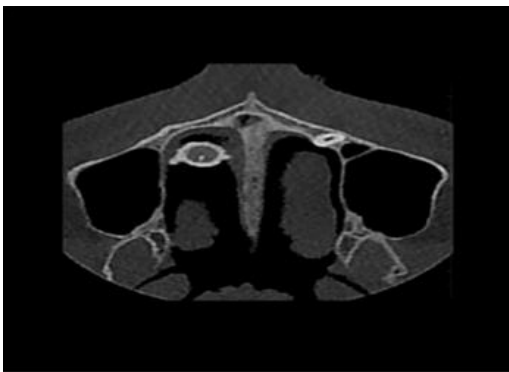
On this axial CBCT view, mucosal thickening of the anterior, lateral, and medial walls of the nasal fossa with central calcification of nidus and atrophic right inferior turbinate can be seen.
